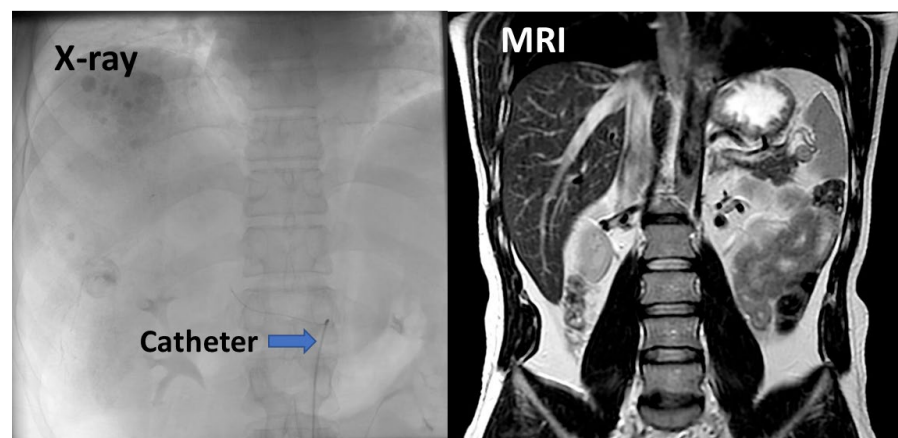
Soft tissue contrast comparison of a chest image between X-ray and MRI.
